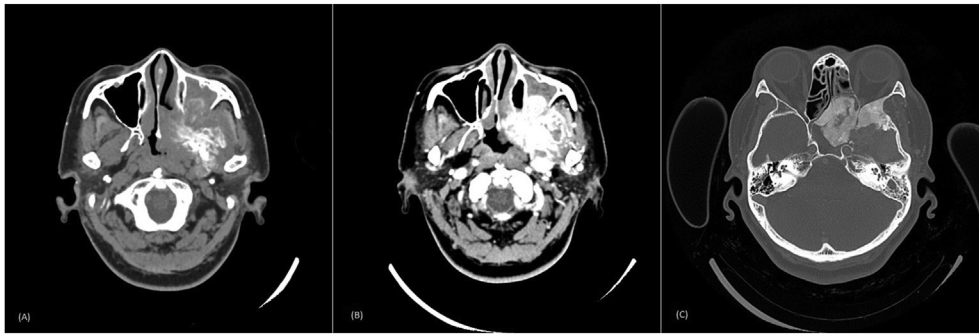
(A, B) Pre and post-contrast head CT images showing an ill-defined mass arising from the left greater sphenoid wing region which is avidly enhancing post-contrast. (C) Bone window showing hyperostosis of the left greater and lesser sphenoid wings and walls of the adjacent sphenoid and ethmoid sinuses.
